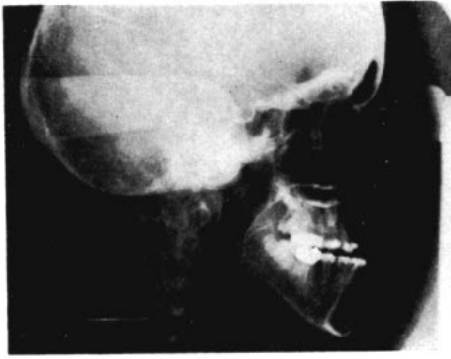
Above: Lateral cephalometric radiograph of cleft palate individual taken during inhalation of air.
